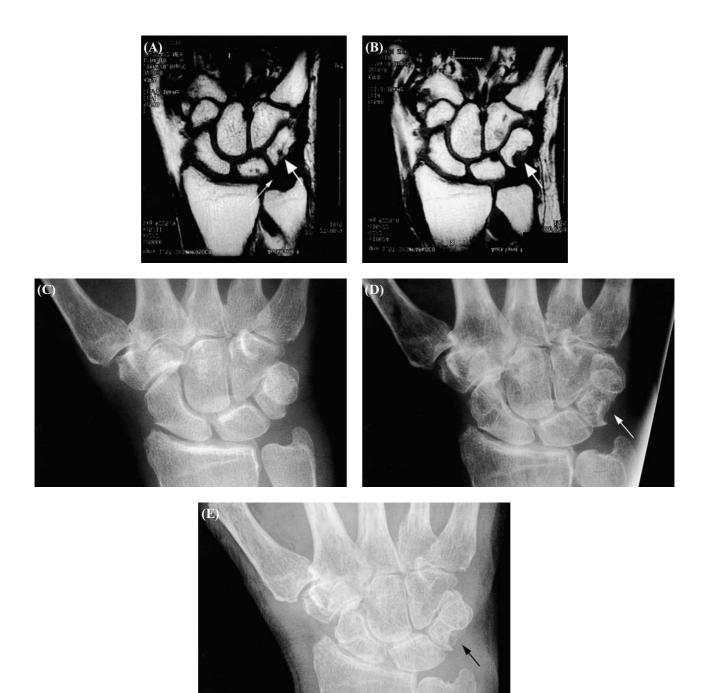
MRI scans ( $T_1$ -weighted coronal images) and X-rays of the dominant wrist from a 63-yr-old woman with early RA. (A) Baseline MRI scan taken 3 months after symptom onset, showing bone marrow oedema within the triquetrum (thick arrow) and adjacent synovial thickening (thin arrow). (B) MRI scan taken 1 yr later shows a large erosion within the triquetrum (arrow). (C) X-ray at baseline did not reveal an abnormality at this site. (D) X-ray 1 yr later revealed the erosion at the triquetrum (arrow). (E) X-ray at 2 yr revealed further erosive change at this site (arrow).
